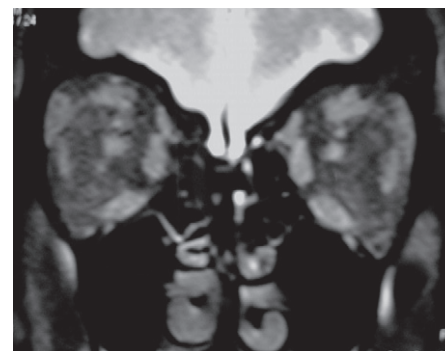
MRI Showing CSF leak
